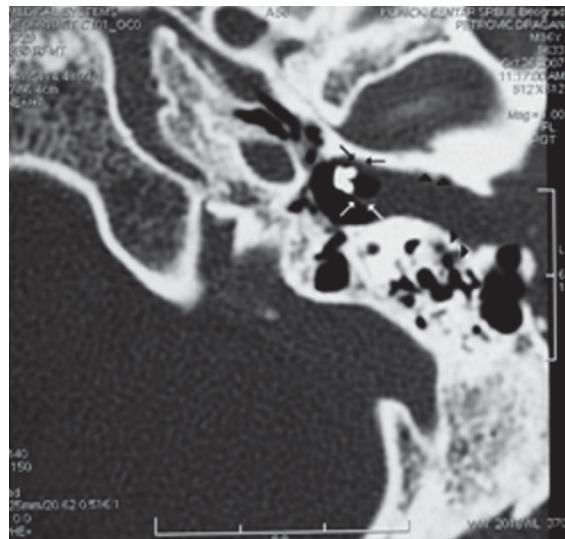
Axial temporal bone computed tomography (CT) image show the soft-tissue mass filling the external ear canal, the superior (black arrowheads) and inferior (white arrowheads) links with ventilation tube insertion; the mass has caused erosion of the canal walls (black arrows)
